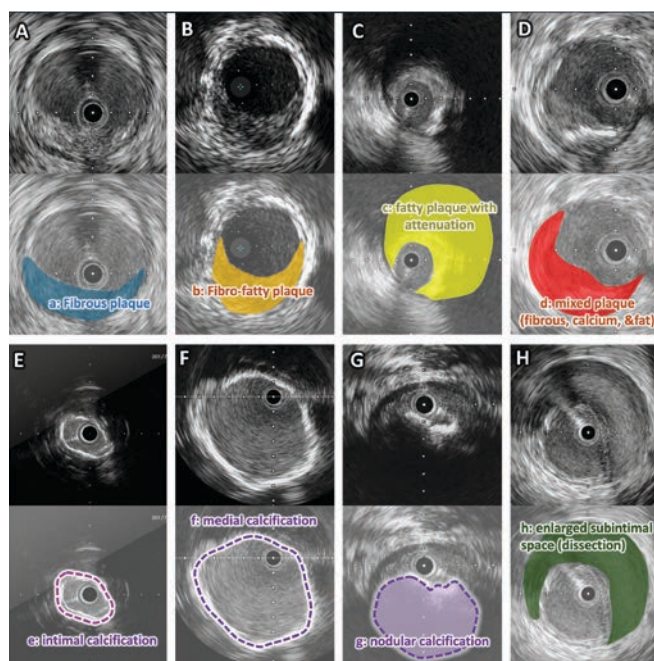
Typical plaque morphologies observed on intravascular ultrasound (IVUS). IVUS provides cross-sectional images of the vessel. In normal vessels, the trilaminar arterial structure is clearly visualized; in diseased segments, accurate assessment of vessel diameter and plaque morphology is particularly important. Atherosclerotic plaque is primarily composed of lipids, fibrous tissue, and calcification, which can be differentiated on grayscale IVUS images based on echogenicity. Lipid-rich plaque typically appears hypoechoic and may demonstrate signal attenuation, resulting in loss of visualization of deeper vessel structures. Fibrous tissue generally appears iso- to relatively hyper-echoic, whereas calcified plaque is highly echogenic and is accompanied by posterior acoustic shadowing because ultrasound does not penetrate calcium. In clinical practice, most atherosclerotic plaques are heterogeneous and consist of varying combinations of these components. (A) Fibrous plaque: The blue area (a) indicates fibrous plaque, which appears as an isoechoic region on IVUS. (B) Fibro-fatty plaque: The orange area (b) represents fibro-fatty plaque, characterized by an iso- to hypoechoic appearance on IVUS. (C) Fatty plaque: The yellow area (c) denotes lipid-rich plaque with signal attenuation, observed as a hypoechoic region. Deeper vessel structures may not be visualized due to acoustic attenuation. (D) Mixed plaque: The red area (d) highlights mixed plaque containing fibrous, lipid-rich, and calcified components, presenting as a heterogeneous echogenic pattern. (E–G) Calcified plaques: These plaques exhibit high echogenicity (greater than that of the adventitia) with posterior acoustic shadowing and are classified as superficial (intimal, e), deep (medial, f), or nodular calcification (g). (H) Subintimal space: The green area (h) indicates an enlarged subintimal space, commonly observed following subintimal guidewire passage and/or balloon-induced dissection.
